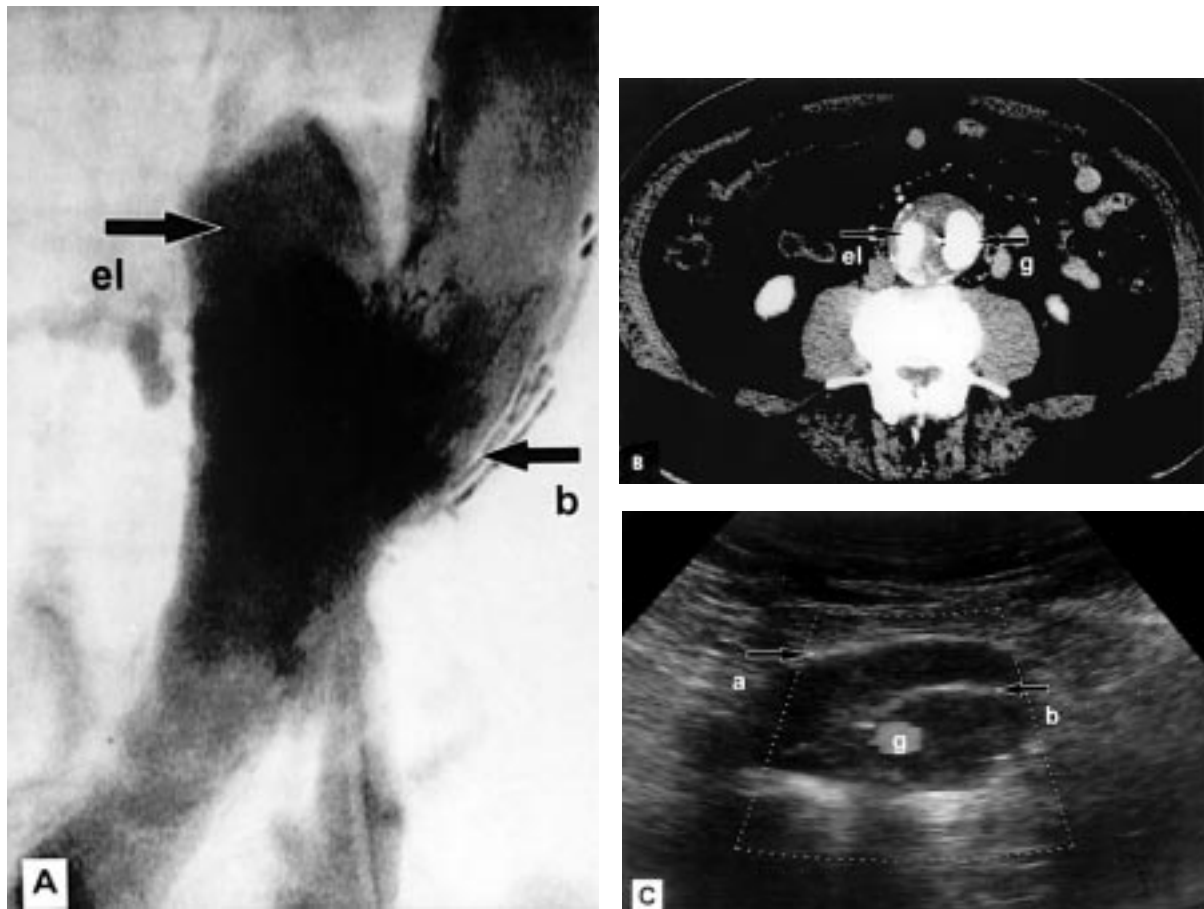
Endovascular repair of endoleak caused by structural failure of previously inserted endovascular graft. Patient was treated with EVT tube graft and experienced delayed distal endoleak 1.5 years after operation when metallic hooks on distal attachment device fractured. A, Arteriogram demonstrates large endoleak (*el*) adjacent to broken distal stent (*b*). B, Endoleak (*el*) can be seen on follow-up CT scan next to endovascular graft (*g*). C, Patient underwent a reparative procedure in which a second endovascular graft was deployed within the first graft. Follow-up duplex scan shows flow in new graft (*g*), which is seen within aneurysm sac (*a*) and within old graft (*b*). There is no evidence of ongoing endoleak.
